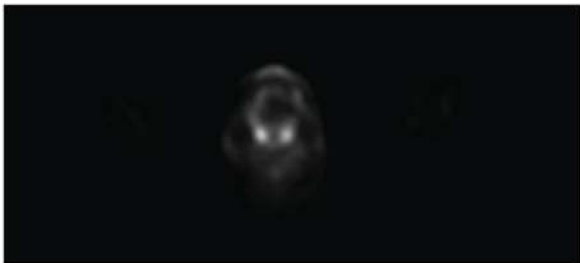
A follow-up axial PET scan images obtained after treatment with antimicrobial therapy for 5 weeks. There is persistent but relatively decreased FDG uptake.
